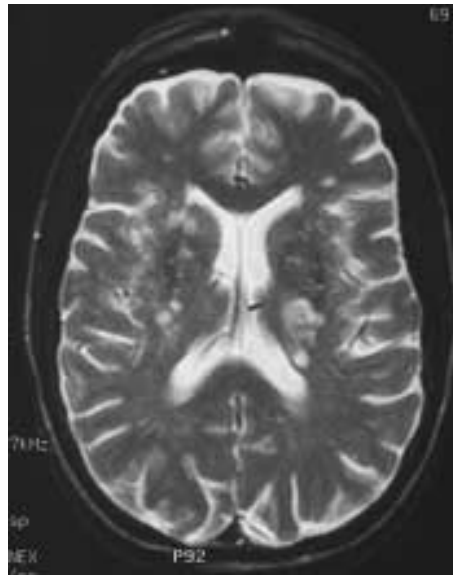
Magnetic Resonance imaging (MRI, T2 images), reveals few high intensity images in the posterior area of the left internal capsule.
